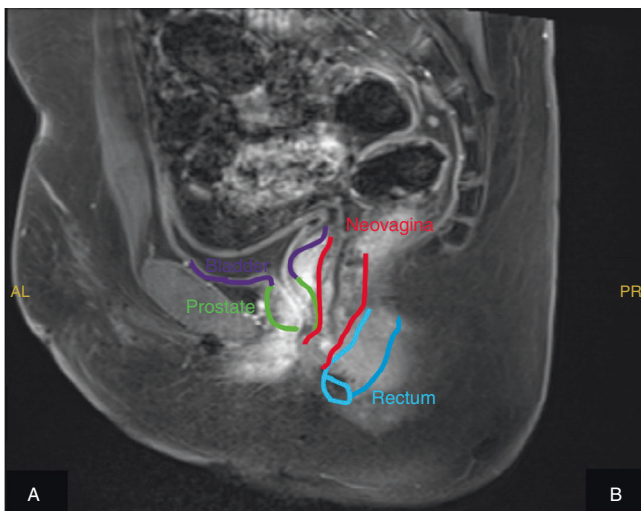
MRI sagittal view from the pelvis of a transgender woman post gender-confirming surgery. Anatomical structures are annotated to highlight the relationship of between the perineum, the prostate (green), neovagina (red), bladder (purple) and rectum (blue).
